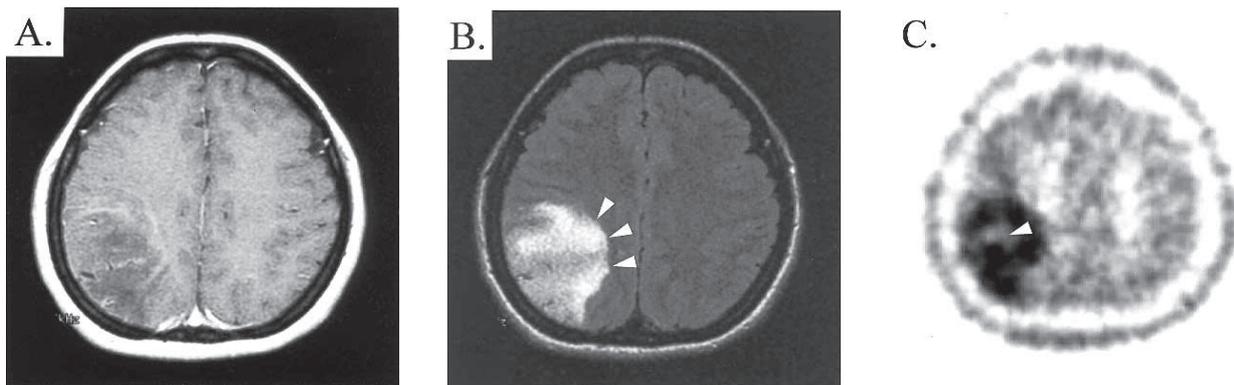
MRI revealed abnormal mass lesion of the right parietal lobe. (A) Gadolinium enhancement image showed low signal and a poorly enhanced lesion. (B) FLAIR image showed high signal in the lesion and slight edema adjacent to the tumor (*white triangles*). (C) Met-PET showed increased uptake by the tumor, but there was slight low uptake area in the tumor (*white triangle*).
